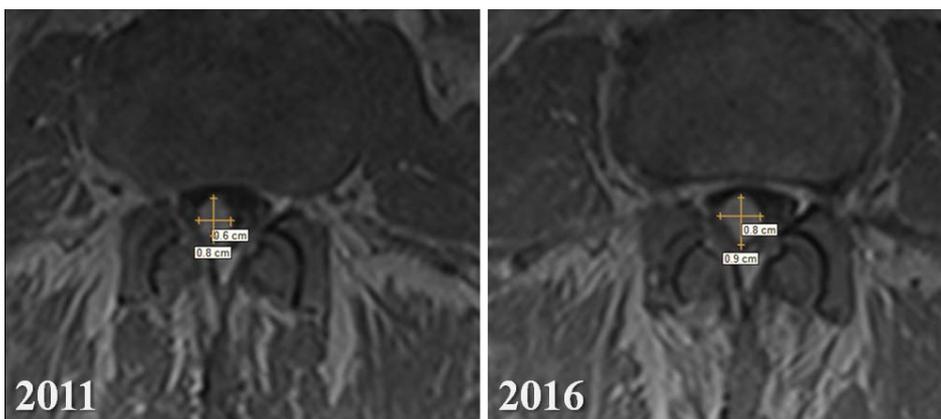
T1-weighted (axial) gadolinium-enhanced MRI images (2011/2016) highlighting the increased size of one of the schwannomas
